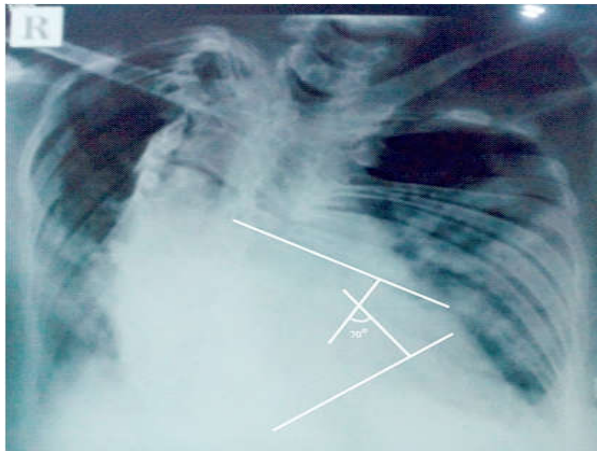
Chest radiograph showing Cobb's angle 70°
